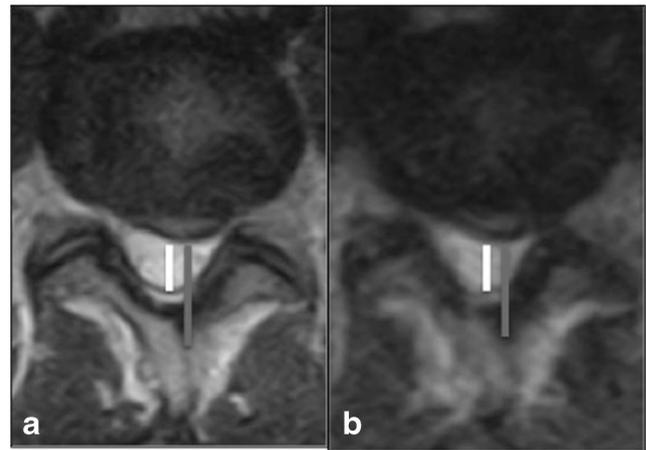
Axial T2-weighted TSE in supine (a) and upright (b) standing. Sagittal midline dural sac (white lines) and spinal canal diameters (gray lines) at L4-L5 level are reduced in b
